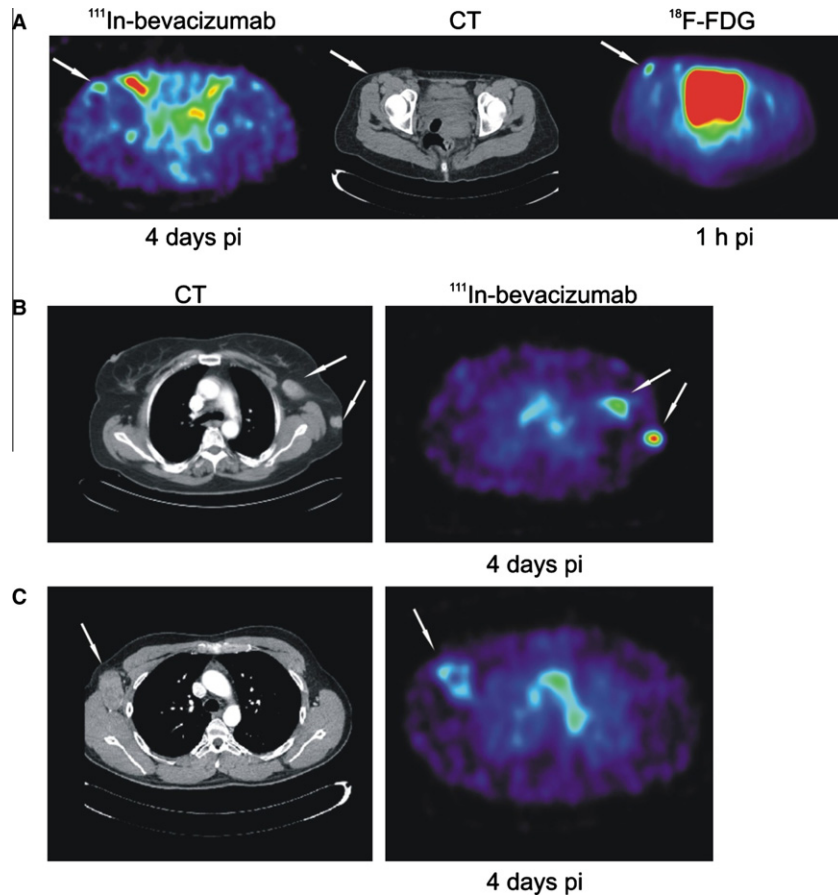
(A) Small melanoma lesions, 16 mm in diameter on CT, detection by ¹¹¹In-bevacizumab, CT imaging and FDG imaging. (B) Differential ¹¹¹In-bevacizumab uptake between two melanoma lesions. (C) Inhomogeneous ¹¹¹In-bevacizumab tumour uptake in melanoma lesion.
